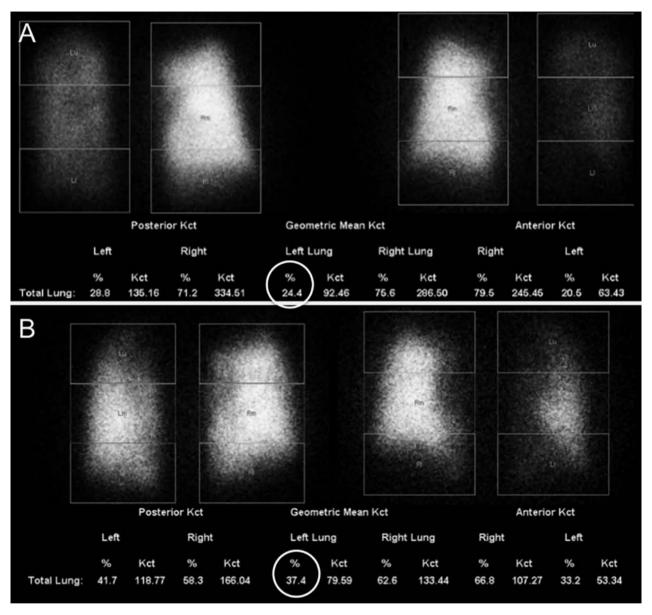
Quantitative perfusion scintigraphy performed before (A) and after (B) artery and venous stenting. At baseline, the left lung only received 24.4% of total lung perfusion (oval, A). After intervention, the flow in the left lung increased to 37.4% (oval, B)
